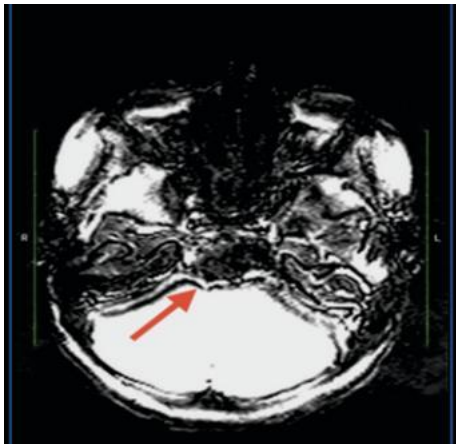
MRI SWI sequence showing blooming artifact suggestive of intralesional hemorrhage.
